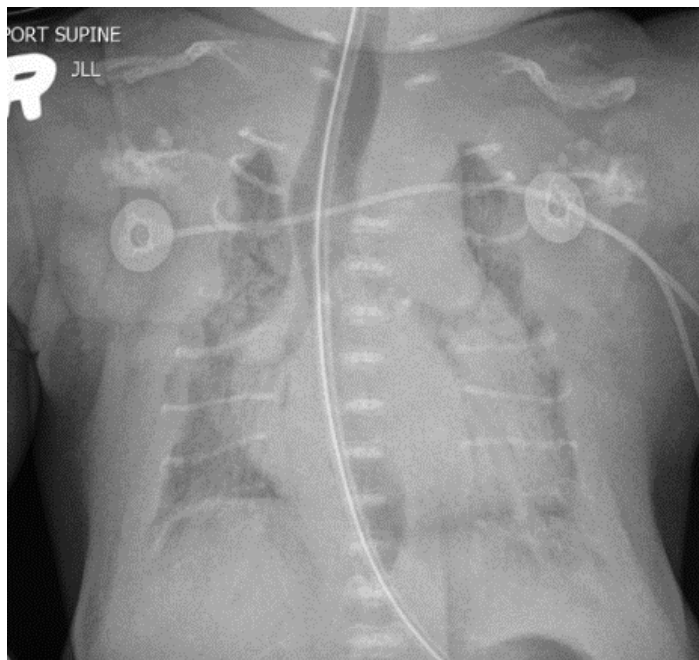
Chest X-rays at birth and at 17 days. Enzyme replacement therapy has not caused an appreciable change in bone mineralization at this point.
